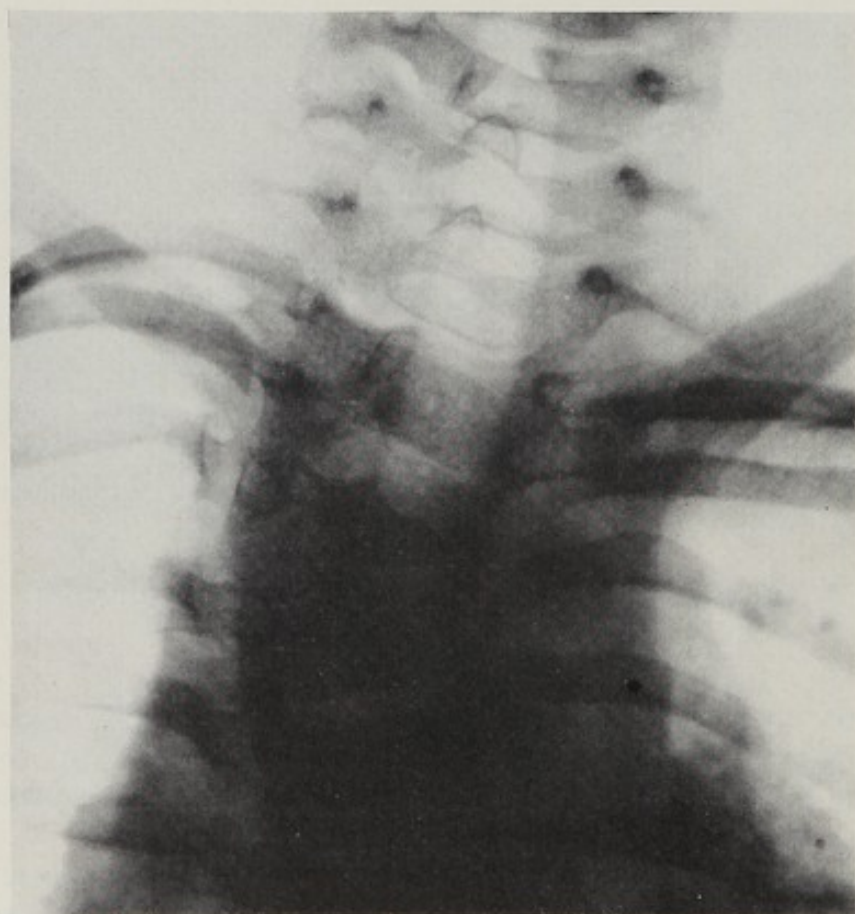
Frontal radiograph of the polydysspondyly.
